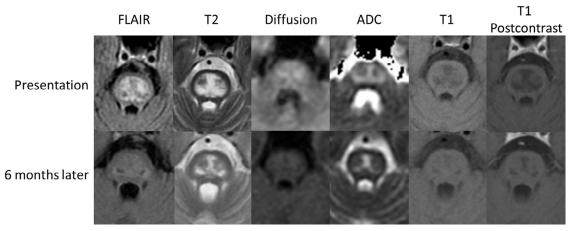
Acute and chronic phases of central pontine myelinolysis. *Left to right:* Axial FLAIR, T2, diffusion, apparent diffusion coefficient (*ADC*), T1, T1 postcontrast. There is "trident" T2 hyperintensity and T1 hypointensity sparing the peripheral pons and corticospinal tracts. There is subtle DWI hyperintensity with ADC hyperintensity at presentation. Six months later, there is diminished T2 and ADC hyperintensity and T1 hypointensity, pontine volume loss, and resolved DWI hyperintensity. No contrast enhancement is seen at either time point.
